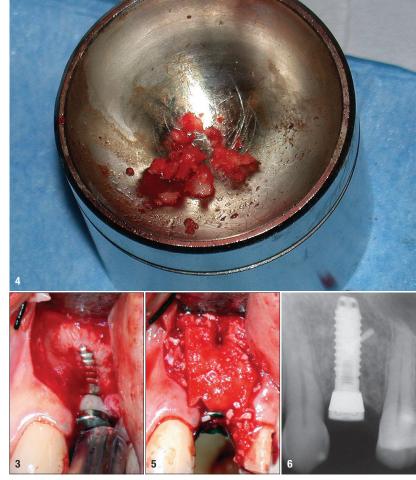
Implant placed in region #24. Fig. 4: Material preparation for the guided bone regeneration. Fig. 5: Placement of the guided bone regeneration material. Fig. 6: Radiograph of the implant in region #24.
